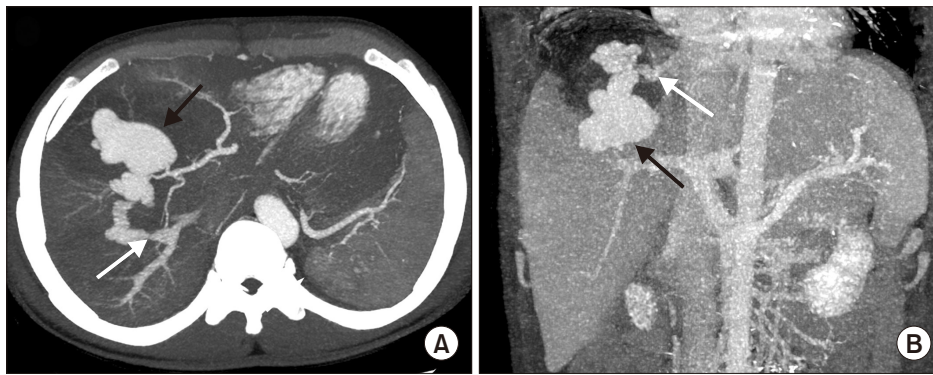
Multislice computed tomography images from the maximum intensity projection of the post-contrast phase (A, B) show a huge pseudoaneurysm of the anterior segmental hepatic artery (black arrows), and arteriohepatic venous fistula (white arrows).
